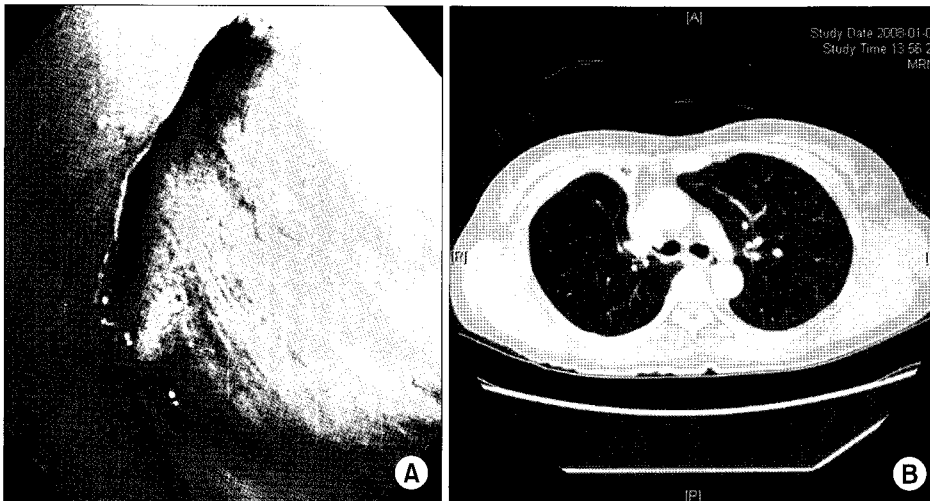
(A) Bronchoscopic findings of the right middle lobar bronchus narrowing which occurred after VATS right upper lobectomy. (B) Chest CT shows slit-like narrowed right middle lobar bronchus.
